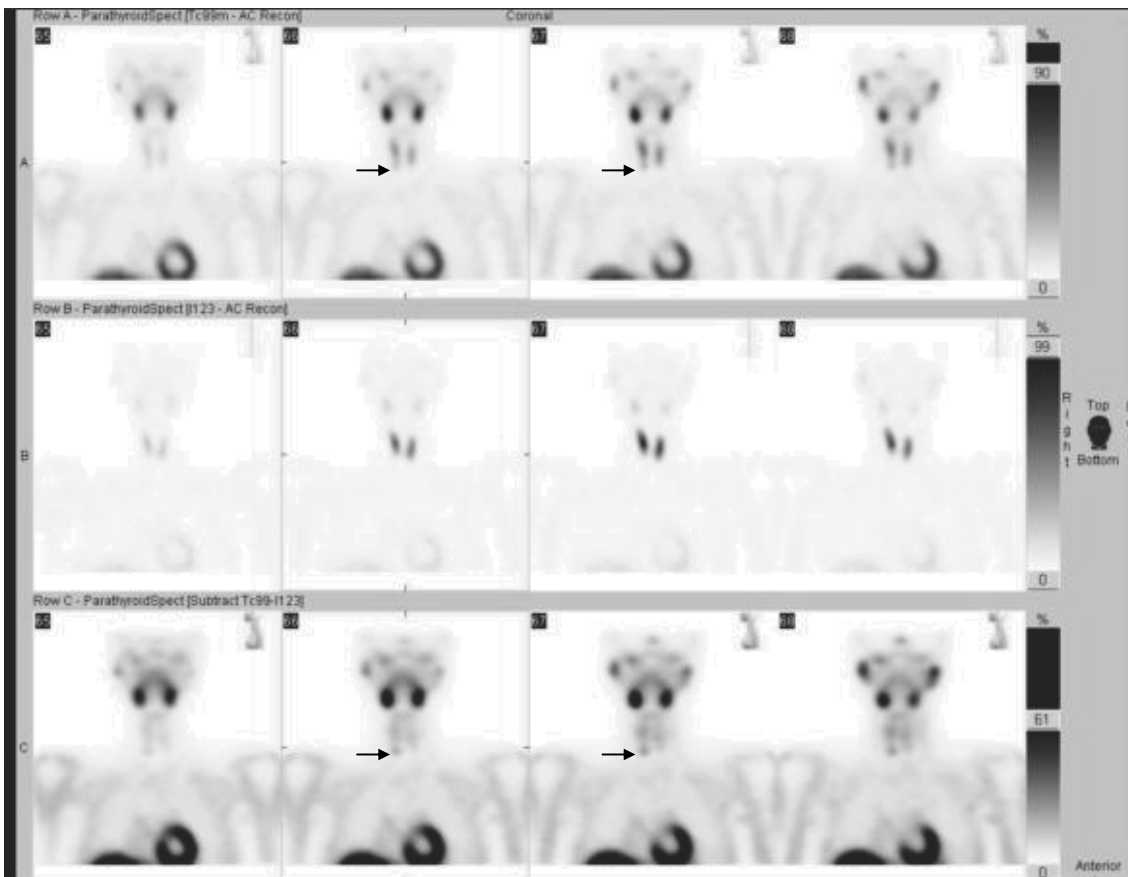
Second nuclear parathyroid scintigraphy using Tc-Sestamibi (arrows point to abnormal right lower parathyroid).
